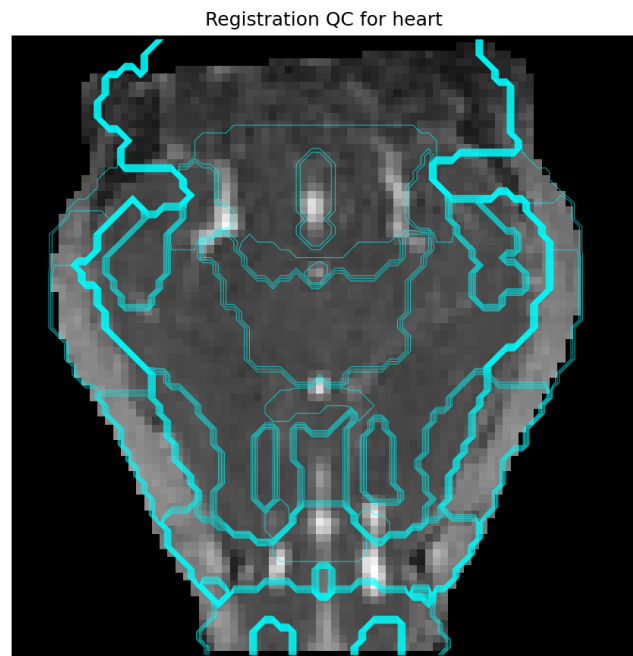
Example of a quality control (QC) plot demonstrating the successful co-registration of an anatomical atlas (cyan contours) to a subject’s b0-weighted magnetic resonance image (grayscale). This visual confirmation of accurate anatomical alignment was essential for ensuring the reliability of regional brain morphometric data used in the study.
